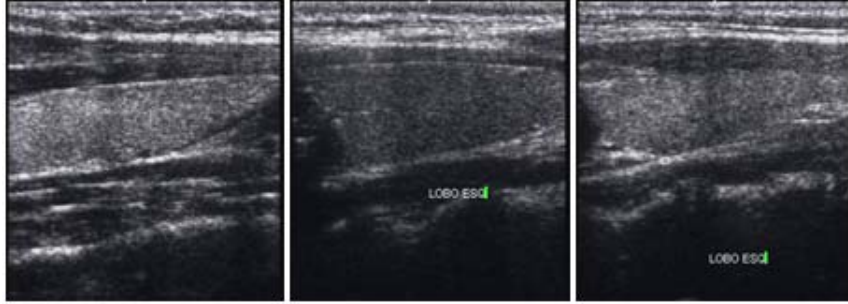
Examples of thyroid ultrasound images, presenting different echo-morphologies. a) Hyperechogenic, b) Hypoechogenic and c) Heterogeneous thyroids.
